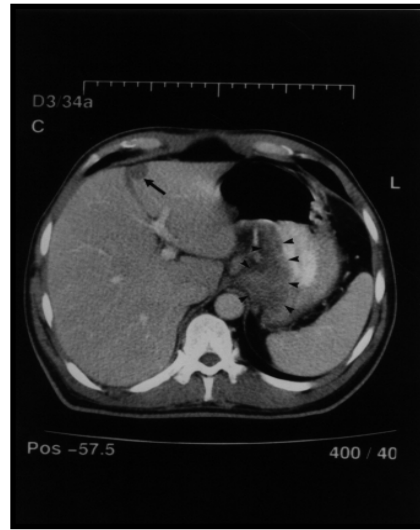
Abdominal computed tomographic picture showing localized gastric wall thickening involving the fundus and the lesser curvature (arrow heads). A tiny hypodense lesion (1.7cm diam) is present on the anterior subcapsular area of the left liver lobe (arrow).
